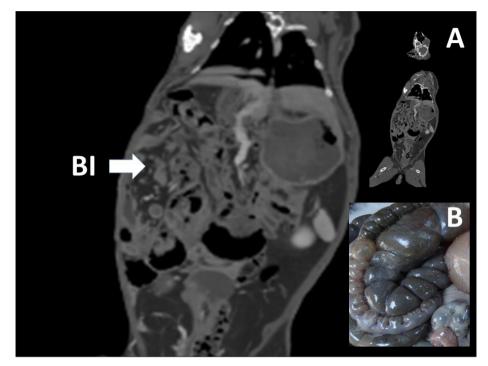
Computed tomography of the abdomen (A) showing dilated edematous intestinal wall and abdomino-peritoneal fluid collections (BI/Base)
